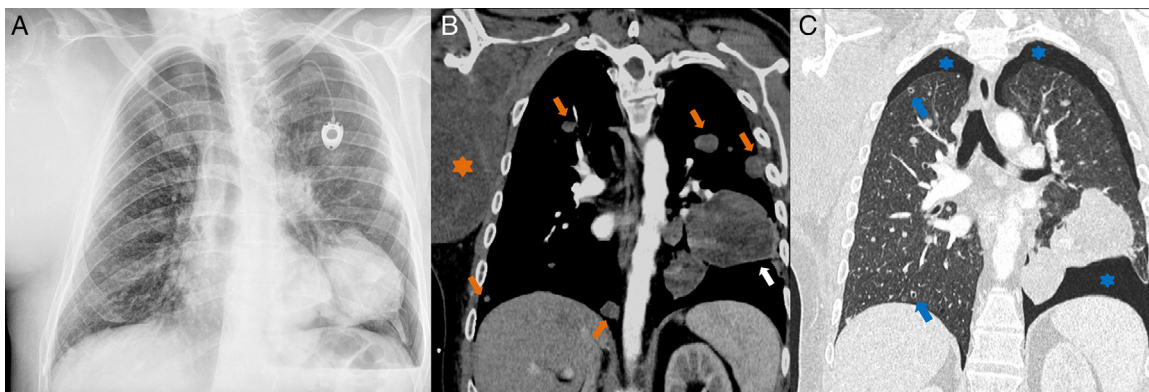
Radiograph (A) and computed tomography (B, C) of the chest in which the sarcoma-axillary level right humerus (orange star) mass in the left lung (white arrow), several solid nodules (orange arrows) are visualized and cavitation (blue arrows) and mild bilateral pneumothorax (blue stars).
